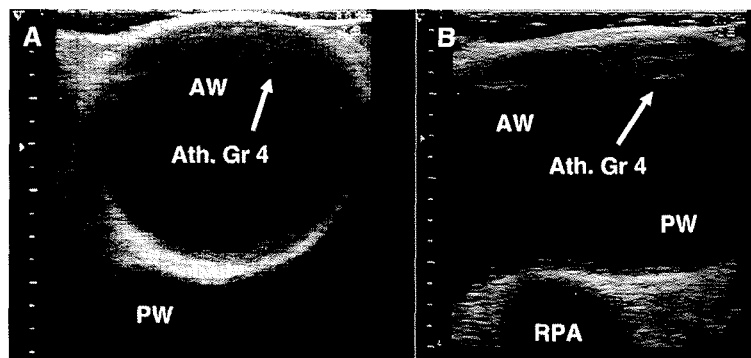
Epiaortic ultrasound scanning of the middle section of the ascending aorta: cross- (A) and longitudinal section views (B). In both views the grade 4 atheroma lesion of the aorta anterior wall is clearly visible. Ath gr 4 = atheroma grade 4; AW = anterior wall; PW = posterior wall; RPA = right pulmonary artery.
